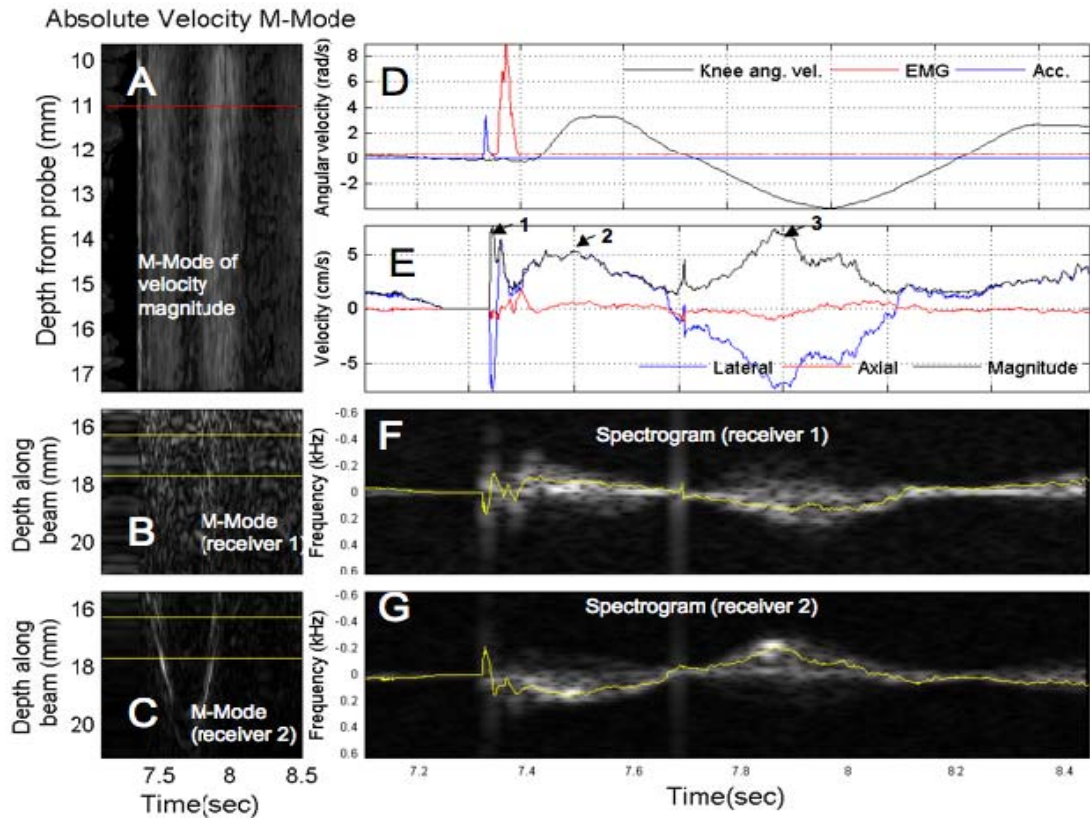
Vector Doppler display. (A) An M-mode display of the estimated velocity magnitude, with time on the horizontal axis and depth on the vertical axis. (B, C) M-mode of the received echoes by receivers 1 and 2, respectively. The yellow lines indicate the region of interest based on the center of the rectus femoris. (D) The joint angular velocity (black), EMG (red) and hammer acceleration signals (blue). (E) The estimated velocity magnitude and the axial (red) and lateral (blue) components. Arrows 1, 2, and 3 represent the elongation, reflex extension and passive flexion velocities. (F, G) Doppler spectrograms of echoes received by receivers 1 and 2, respectively. The yellow lines represent the detected velocities.
